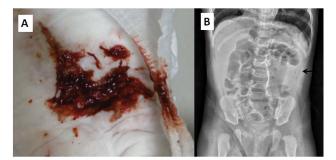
(A) Currant jelly stool was noted in diaper; (B) Abdominal radiograph show gas-dilated loops and no gas in distal intestine (black arrow).
